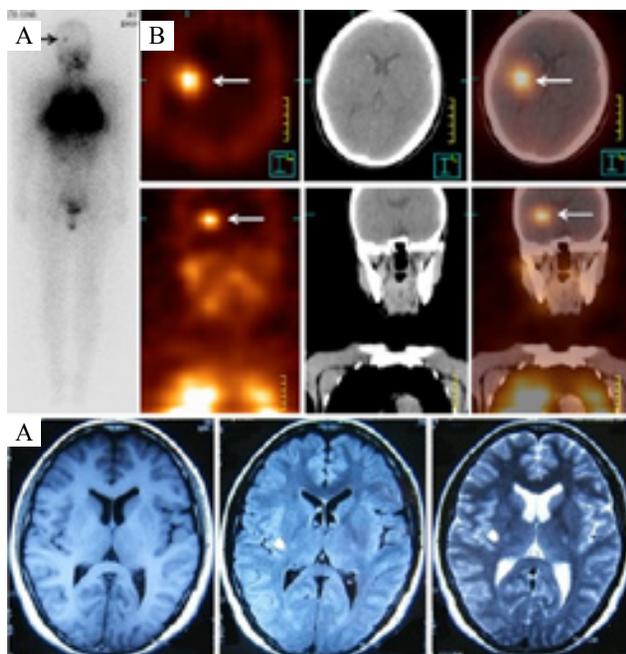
A patient with lung metastases was treated with ^{131}I . Posttherapeutic ^{131}I -WBS showed intense ^{131}I uptake in the lungs. There is a small and faint ^{131}I accumulation lesion in the right brain (A, arrow), which could have been easily overlooked. The subsequent ^{131}I -SPET/CT revealed that was a small ^{131}I -avid mass in the right brain (B, arrows) and MRI further demonstrated that it was a small lesion in the right brain of basal ganglia (C), which corresponded well to the ^{131}I -SPET/CT images and could precisely localize the foci of ^{131}I uptake.
